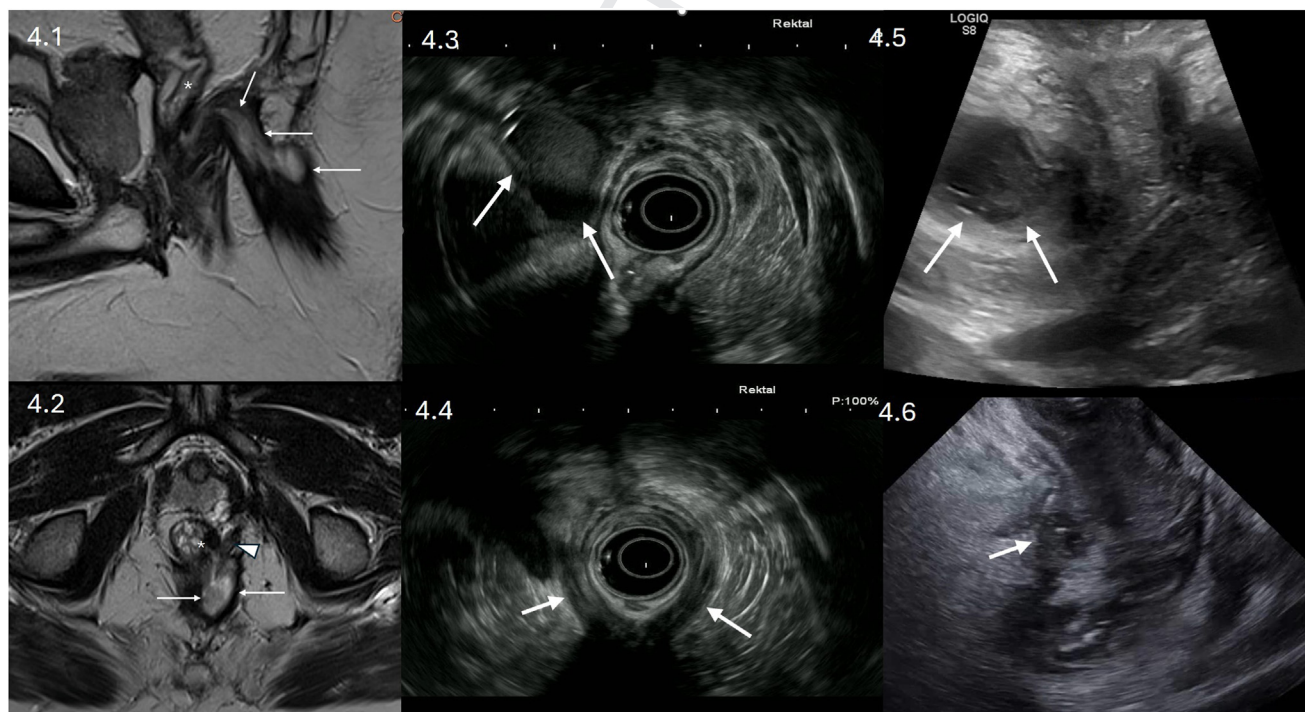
(4.1) MRI: Sagittal T2-weight fast-spin echo image from a pelvic MRI study from a 36-year-old male patient with CD showing an extra-sphincteric fistula (arrows) arising from an inflamed distal rectum (*) demonstrating high T2 signal in the bowel wall. (4.2) MRI: Axial T2-weight fast-spin echo image from a pelvic MRI study from the same patient as 4.1 showing 1.4-cm abscess (arrows) lateral to the puborectalis muscle (arrowhead) in the roof of the left ischioanal fossa complicating an extrasphincteric fistula arising from the distal rectum at 5 o'clock (*). (4.3) TRUS: Abscess (arrows) in the ischioanal fossa in a 29-year-old man with perianal CD (L3B3p) with complex fistulae. L3, ileocolonic; B3, penetrating; p, perianal disease modifier. (4.4) TRUS: Horseshoe fistula (arrows) in the same patient. (4.5) TPUS: Perianal abscess (arrows) in a 27-year-old man with CD L3B3p. (4.6) TPUS: Transsphincteric fistula (arrows) in a 52-year-old man with perianal CD.
